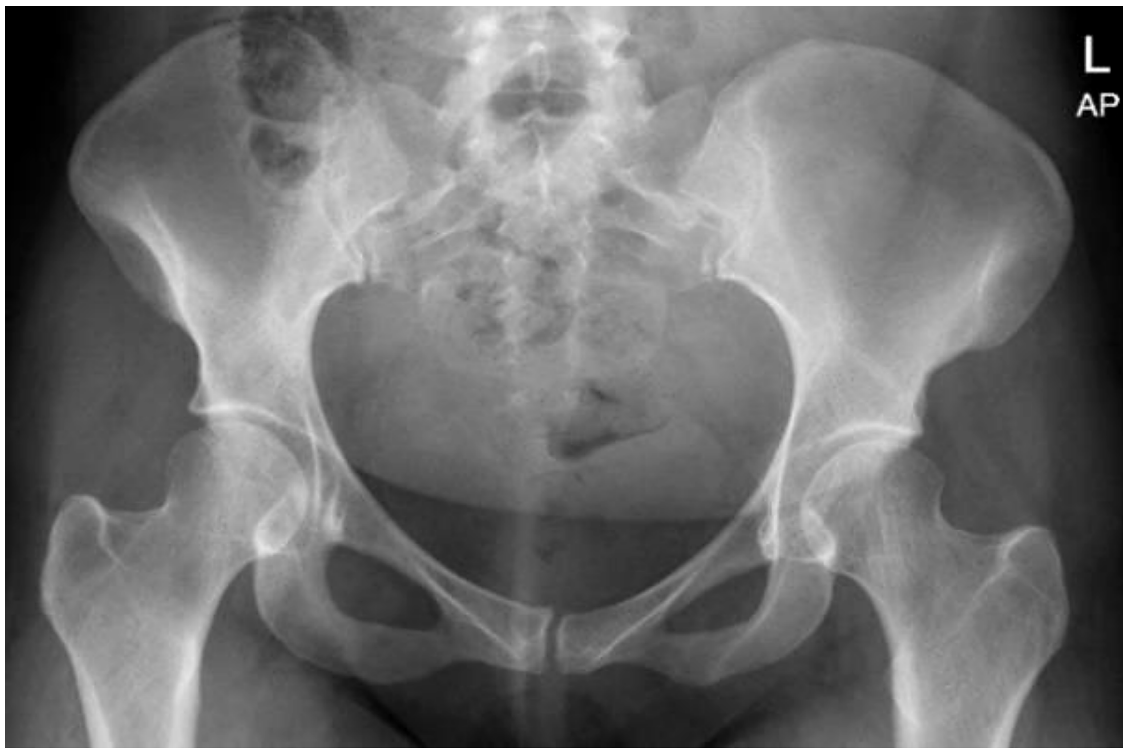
Anteroposterior pelvis radiograph of the reported case.
